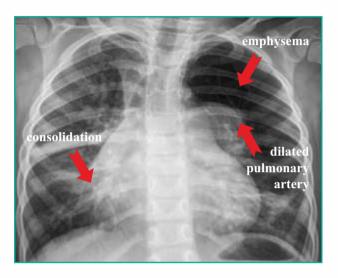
Chest X-Ray revealed moderately enlarged heart with massive dilated left and right pulmonary arteries & proximal main pulmonary artery aneurysmal. Right pulmonary vascular marking more prominent than left. Hyperinflation of left upper lobe and left lower lobe atelectasis.
